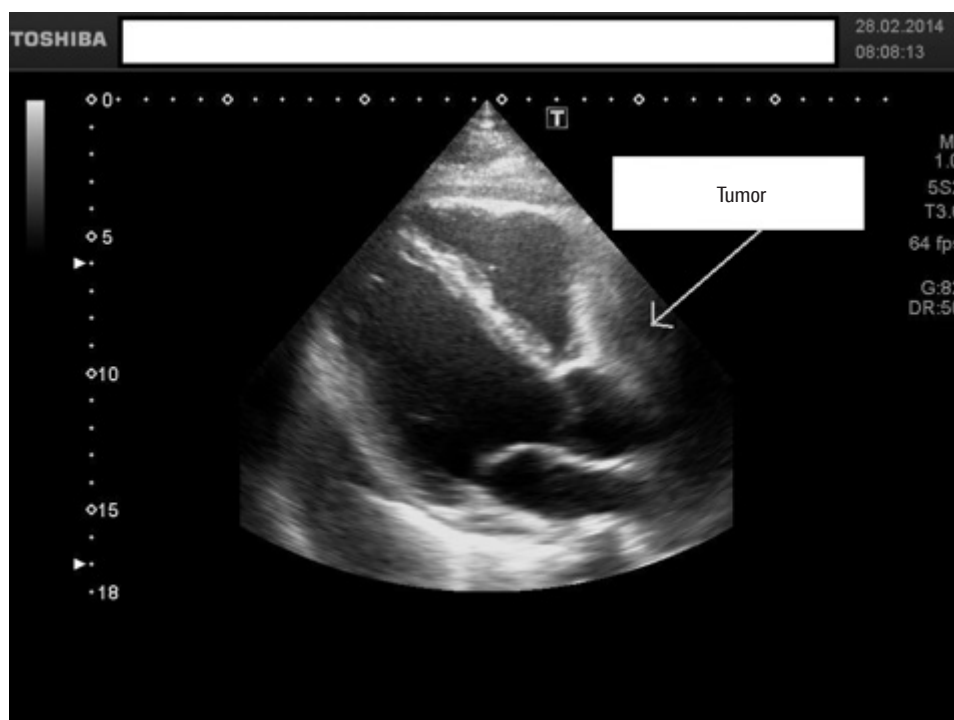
Echocardiography: tumor pressure on the free wall of the right ventricle
